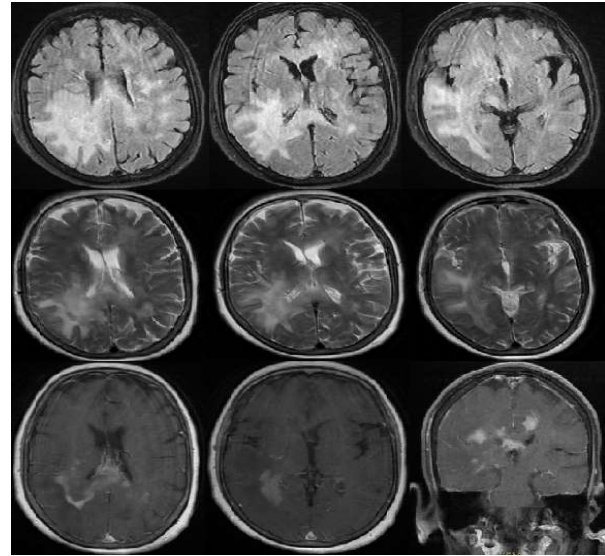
Atypical lesions in recent Brain MRI; diffuse large B cell lymphoma was confirmed.
